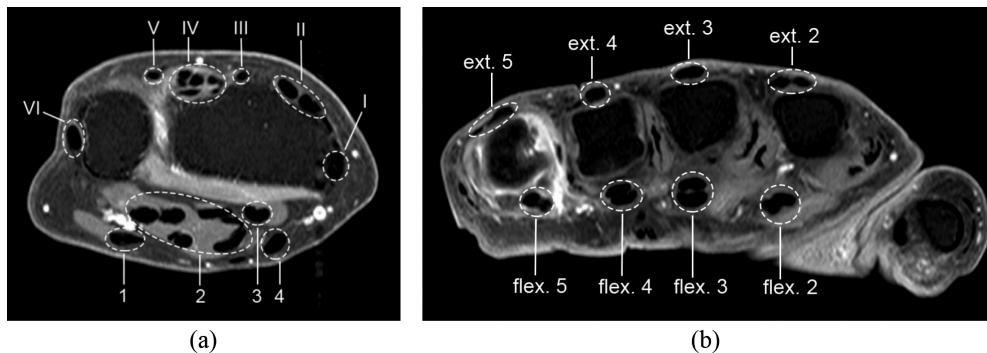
Tendon regions (compartments) scored for tenosynovitis in the wrist (a) and the MCP joints (b), shown on axial MR images (T1, post-gadolinium, fat-saturated). In the wrist, the six defined extensor compartments contain: abductor pollicis longus, extensor pollicis brevis (I); extensor carpi radialis longus, extensor carpi radialis brevis (II); extensor pollicis longus (III); extensor digitorum communis, extensor indicis proprius (IV); extensor digiti quinti proprius (V); extensor carpi ulnaris (VI). The four flexor regions in the wrist contain: flexor carpi ulnaris (1); ulnar bursa, including flexor digitorum profundus and superficialis tendon quartets (2); flexor pollicis longus (tendon) in radial bursa (3); flexor carpi radialis (4). In the MCP joints, the four extensor regions (ext. 2–5) contain the extensor tendons of the fingers, and the four flexor regions (flex. 2–5) contain the paired flexor tendons, corresponding to MCP joints 2–5. Note: extensor tendons at the MCP level and the flexor carpi ulnaris at the wrist do not have a tenosynovial sheath; nevertheless, inflammation around these tendons is also observed, and therefore enhancement of tissue surrounding these tendons is scored [18].
